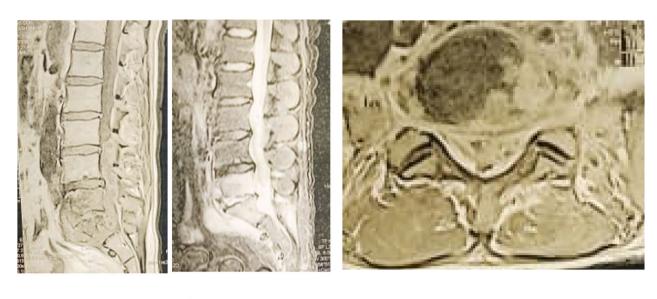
L4-5-S1 spondylodiscitis. a-f Preoperative MRI LSS T1, T2, T1 with contrast showed L4-L5-S1 spondylodiscitis. g, h postoperative MRI LSS; showed L4-L5-S1 fixation by transpedicular screws and posterior decompression by L4-5 laminectomy and debridement
